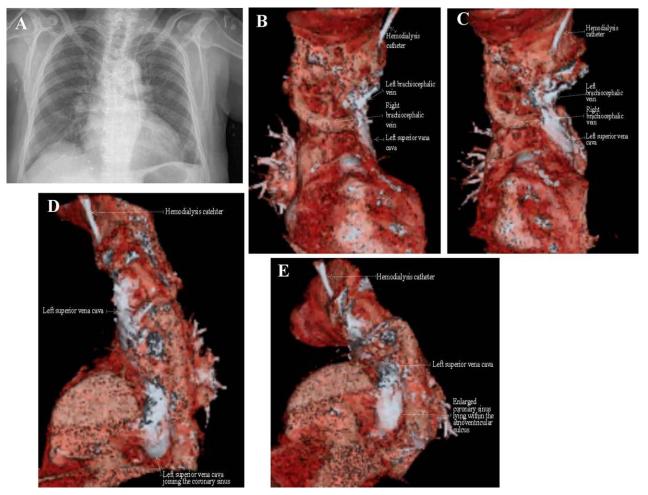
(A) Posteroanterior chest X-ray shows that the left internal jugular vein catheter is descenting straightly on the left parasternal border. (B and C) Anterior and anterolateral views of three-dimensional reconstruction of thorax computed tomography with contrast injection through the left arm show that the right brachiocephalic vein fuses with the left brachiocephalic vein to form the left superior vena cava, and the catheter is seen entering the left internal jugular vein. The right superior vena cava is absent. (D and E) Lateral and inferolateral views show that the left superior vena cava continues to drain into the coronary sinus, which is located within the atrioventricular sulcus and enlarged.
